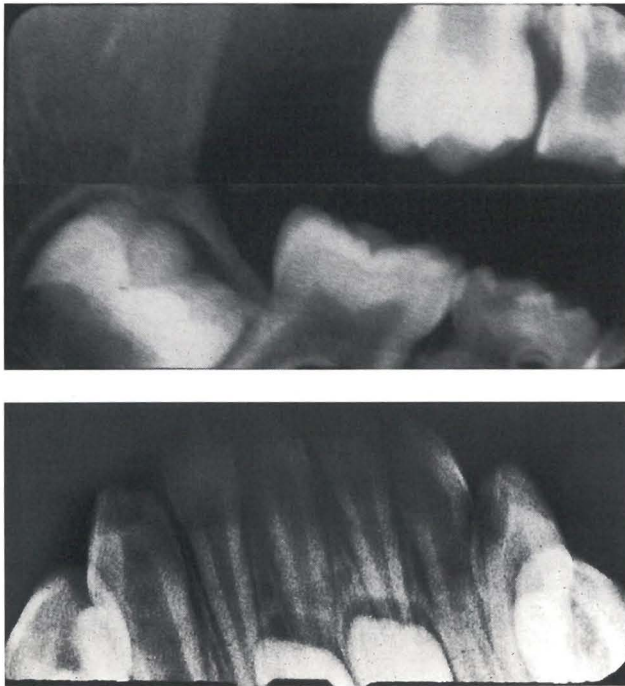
Bitewing radiograph of the right posterior, mandibular anterior occlusal radiograph, and bitewing radiograph of the left posterior respectively showing relative taurodontism of the pulp chambers of the primary molars.
